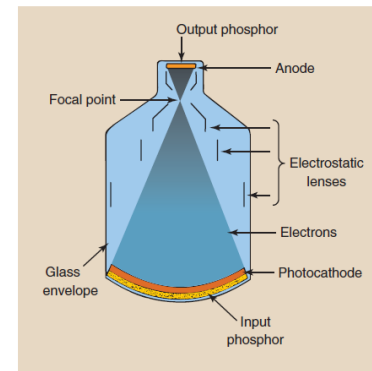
The image-intensifier tube converts the pattern of the x-ray beam into a bright visible-light image.
